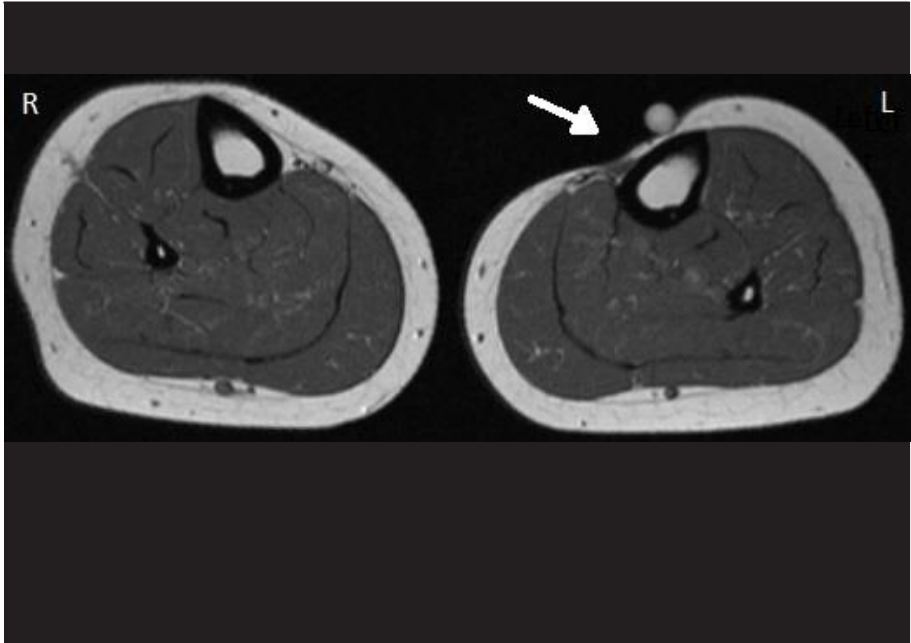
MRI of both mid shaft tibia shows on the left tibia subcutaneous edema with a decrease in the amount of subcutaneous fat tissue at the injection sites (arrow).
